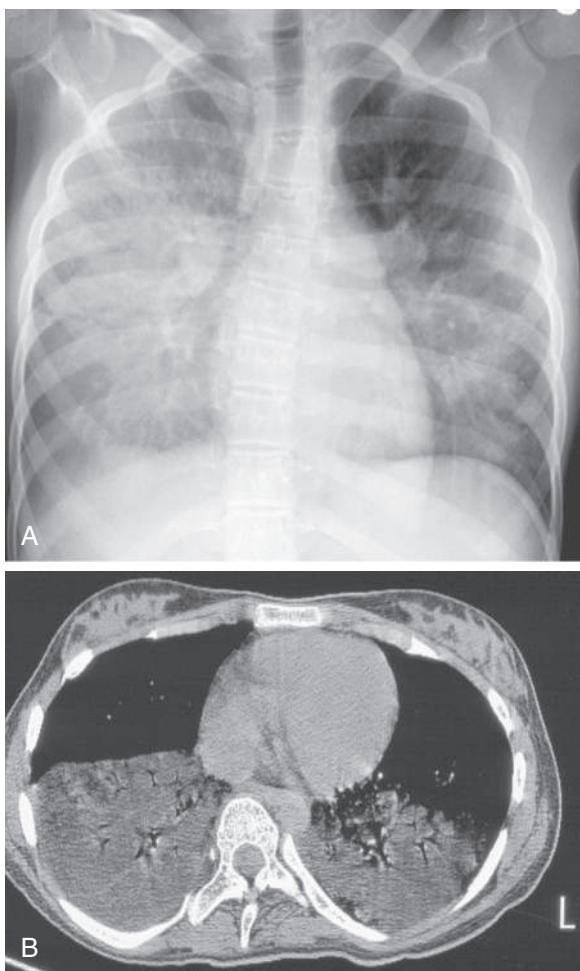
A, Chest radiograph of a developmentally delayed 15-yr-old with chronic aspiration of oral formula. Note posterior (dependent areas) distribution with sparing of heart borders. B, Chest CT scan of same patient. Note lung consolidation in dependent regions is of similar density to subcutaneous fat.
